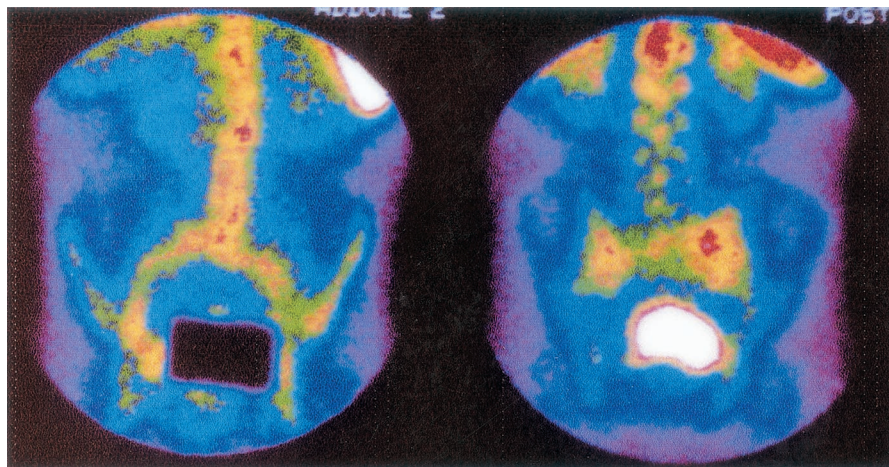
Technetium 99 scintigraphy shows diffuse leukocyte activity in retroperitoneal space, with most significant gain localized along endoprosthesis.
